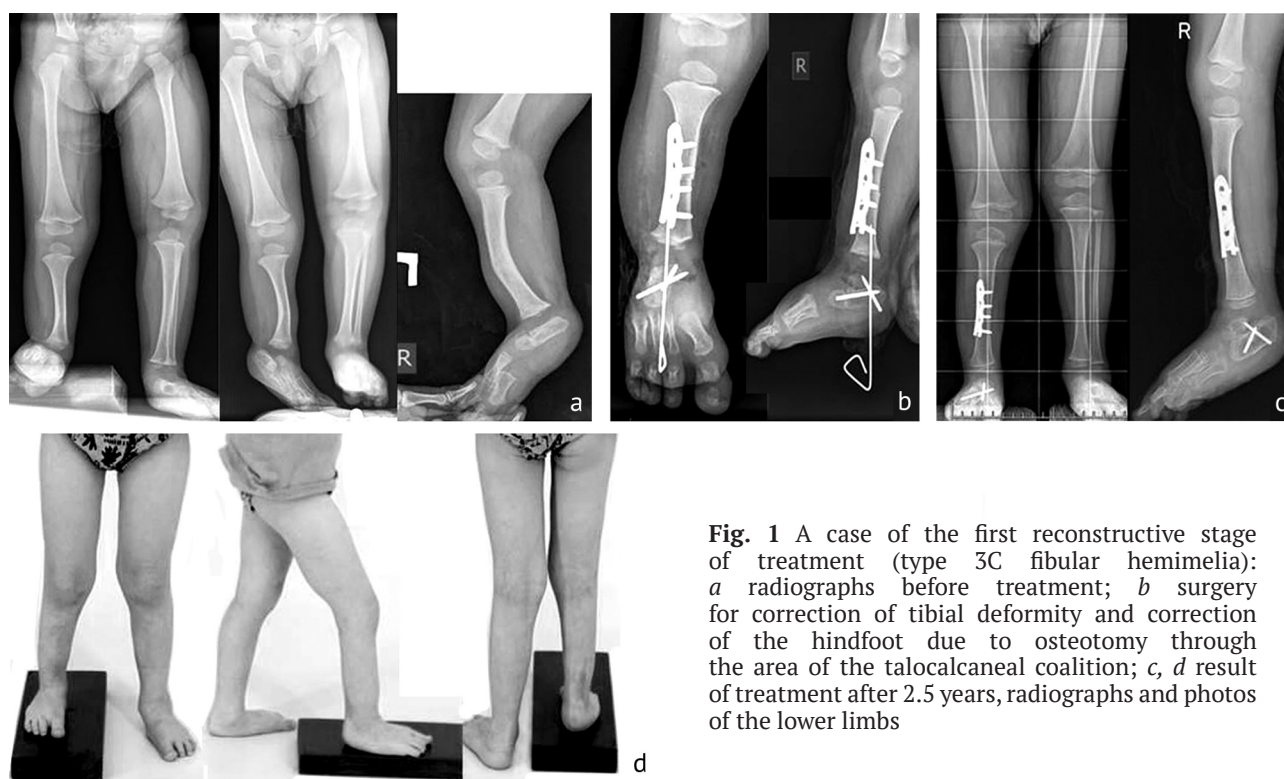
A case of the first reconstructive stage of treatment (type 3C fibular hemimelia): *a* radiographs before treatment; *b* surgery for correction of tibial deformity and correction of the hindfoot due to osteotomy through the area of the talocalcaneal coalition; *c, d* result of treatment after 2.5 years, radiographs and photos of the lower limbs
